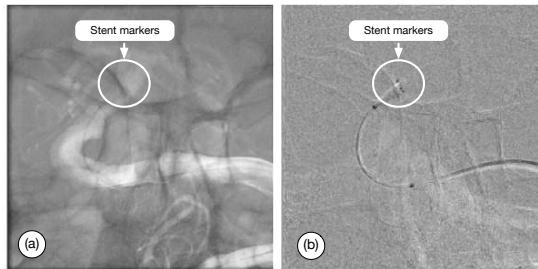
(a) The original X-ray image from a clinical dataset. (b) Background subtracted image with improved stent marker visualization
